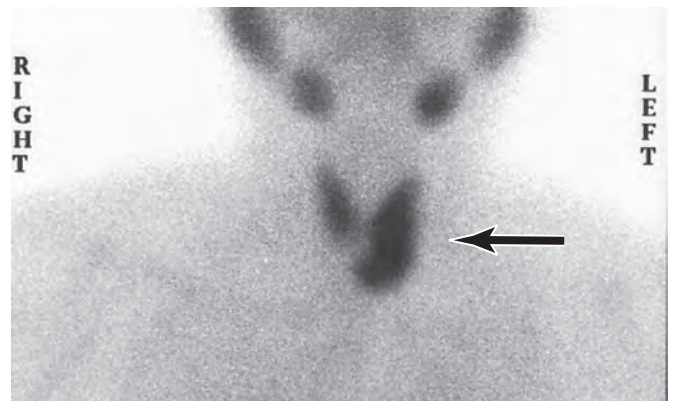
Parathyroid adenoma imaging. Technetium-99m-sestamibi radionuclide scan demonstrates an area of increased uptake corresponding to the left inferior parathyroid gland (arrow), which contained a parathyroid adenoma. Preoperative scintigraphy is useful in localizing and distinguishing adenomas from parathyroid hyperplasia, where more than one gland demonstrates increased uptake.
